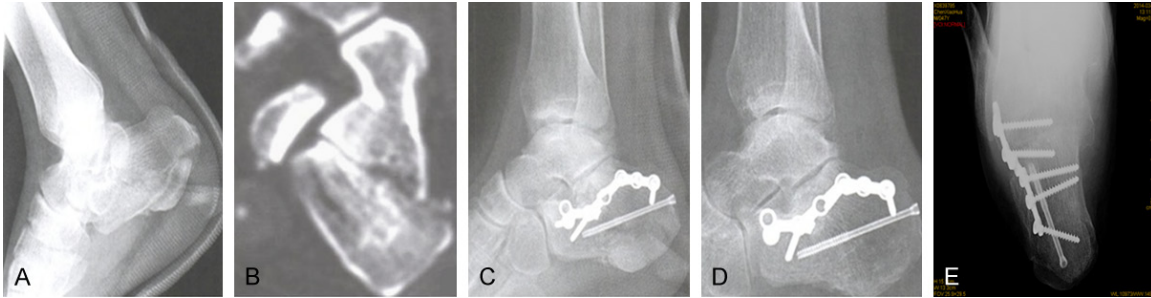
One case of intra-articular *tongue-type* calcaneus fractures treated via sinus tarsi approach with modified calcaneal plate (n=48 feet, 40 patients). A. Preoperative X-ray image of calcaneus. B. Preoperative CT image of Sanders III fracture. C. Postoperative X-ray image of calcaneus (satisfied fixation). D. X-ray image after fracture healing (no significant loss of reduction). E. Postoperative X-ray image of axial calcaneus with internal fixation.
